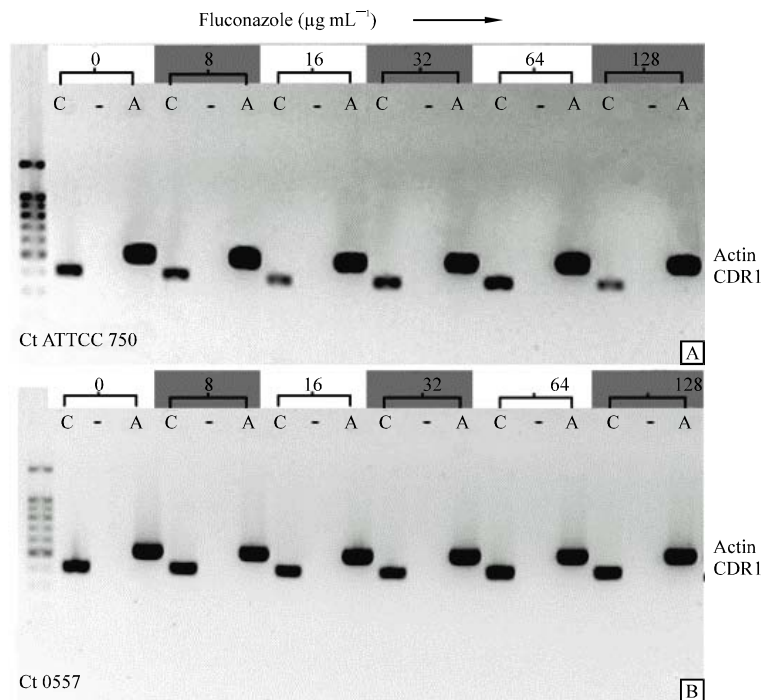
RT-PCR analysis of CtCDR1 and Actin genes for drug susceptible *Candida tropicalis* CT ATCC 750 (A) and drug resistant isolate Ct0557 (B) after induction with increasing fluconazole concentrations. ['C' = CtCDR1, '-' = without MMLV reverse transcriptase, 'A' = Actin] Both isolates were subjected to culture at increasing concentrations of fluconazole. RNA was extracted and then subjected to semi-quantitative RT-PCR to assess the relative gene expression of CtCDR1 gene using actin gene as housekeeping gene control
